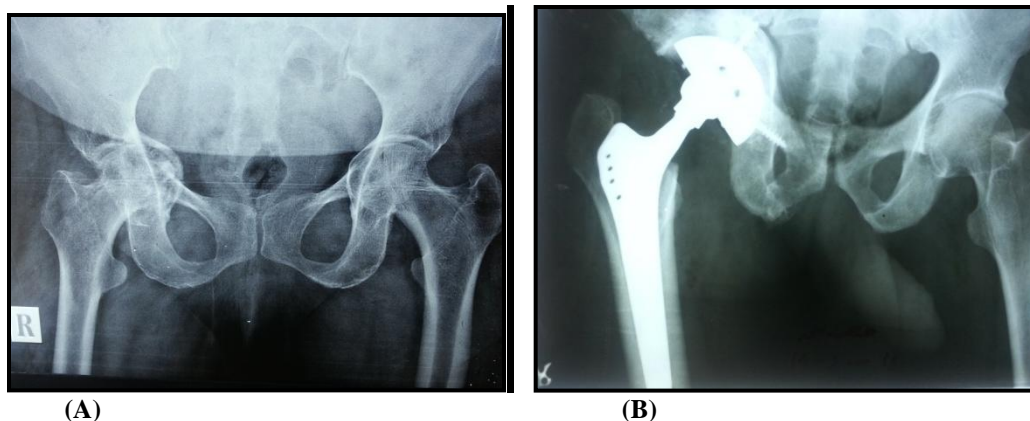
Plain x-ray of right hip of Sixty five years old lady with right protrusion acetabulum (A), after cementless total hip replacement (B).
